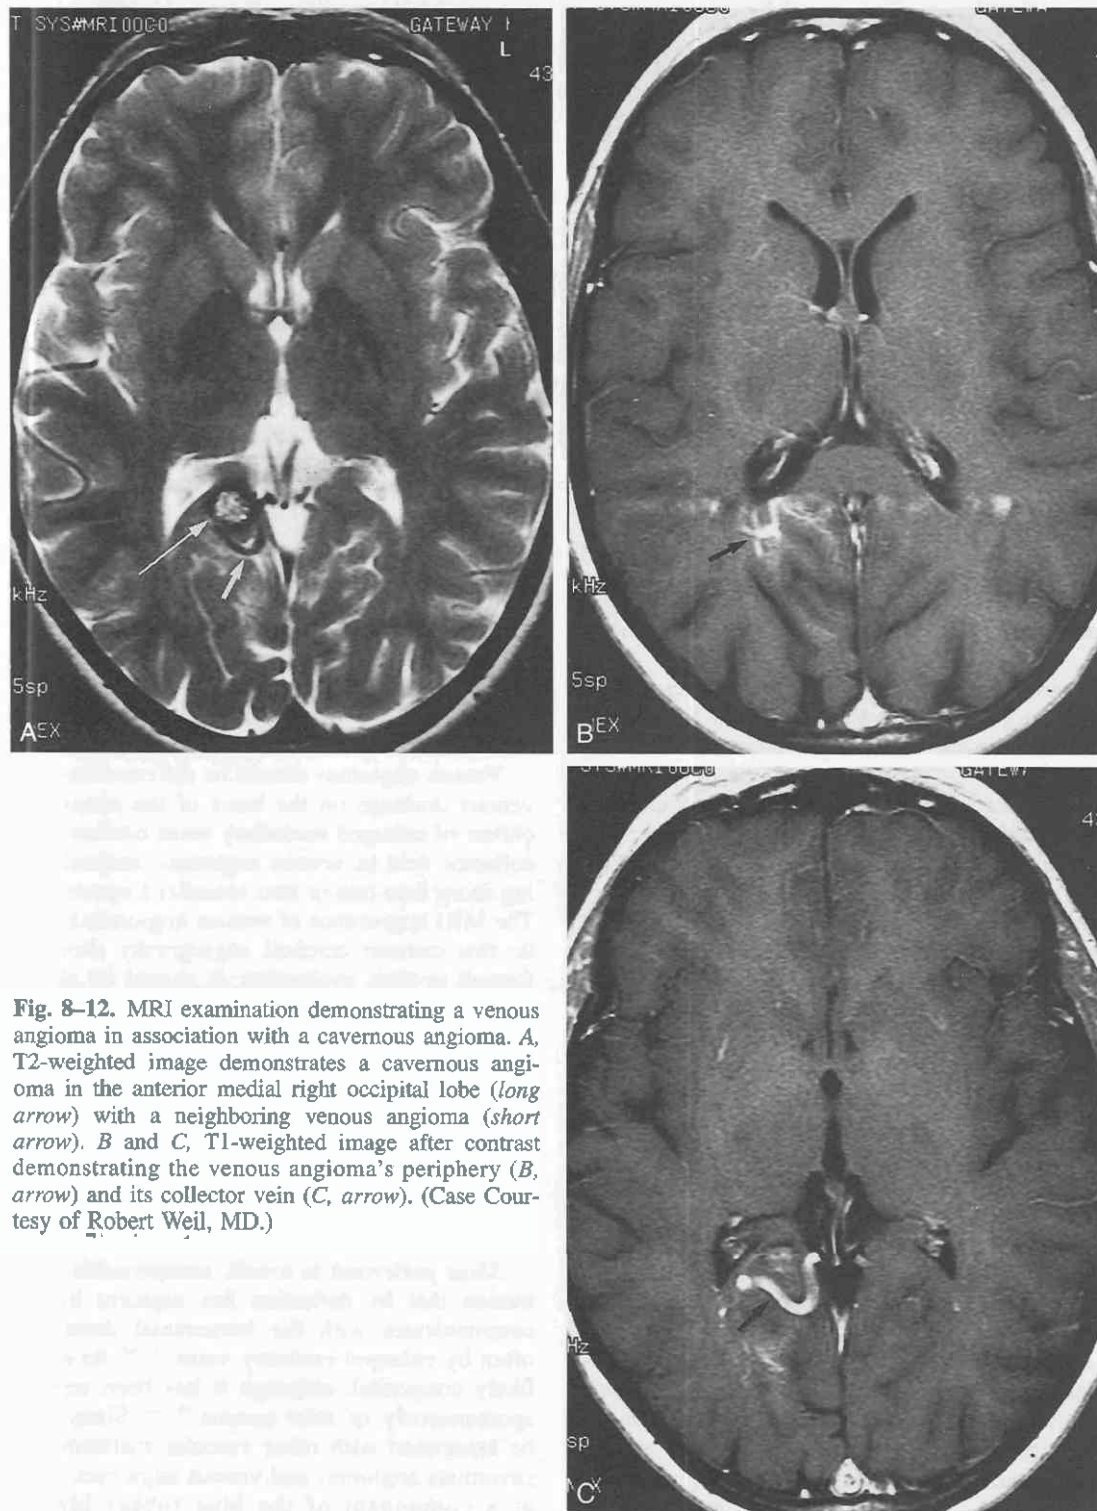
MRI examination demonstrating a venous angioma in association with a cavernous angioma. A, T2-weighted image demonstrates a cavernous angioma in the anterior medial right occipital lobe (long arrow) with a neighboring venous angioma (short arrow). B and C, T1-weighted image after contrast demonstrating the venous angioma's periphery (B, arrow) and its collector vein (C, arrow). (Case Courtesy of Robert Weil, MD.)
